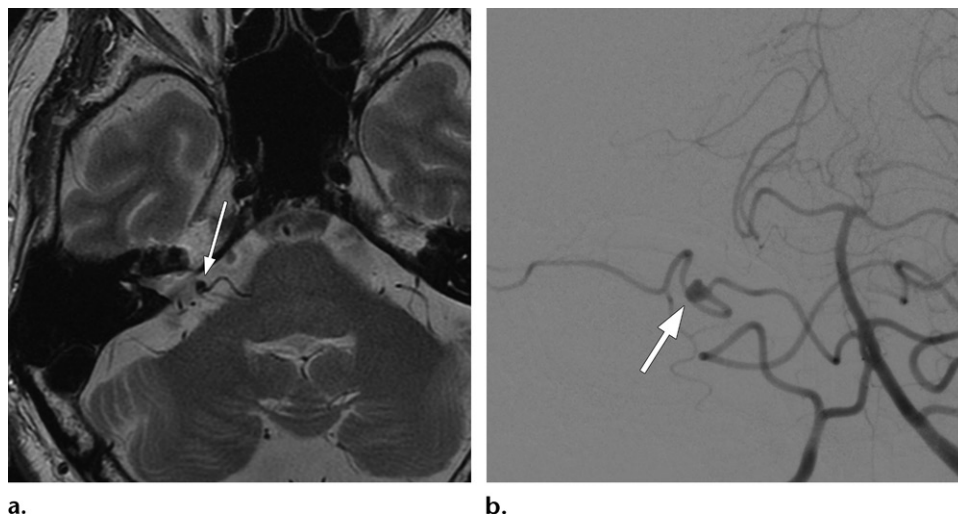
Intracranial aneurysm in a 67-year-old man who underwent stereotactic radiosurgery for a right vestibular schwannoma in the right internal auditory canal. Axial T2-weighted image (a) and frontal projection from digital subtraction arteriography of the vertebral artery (b) 9 years later show a saccular aneurysm (arrow) of the right anterior inferior cerebellar artery.
